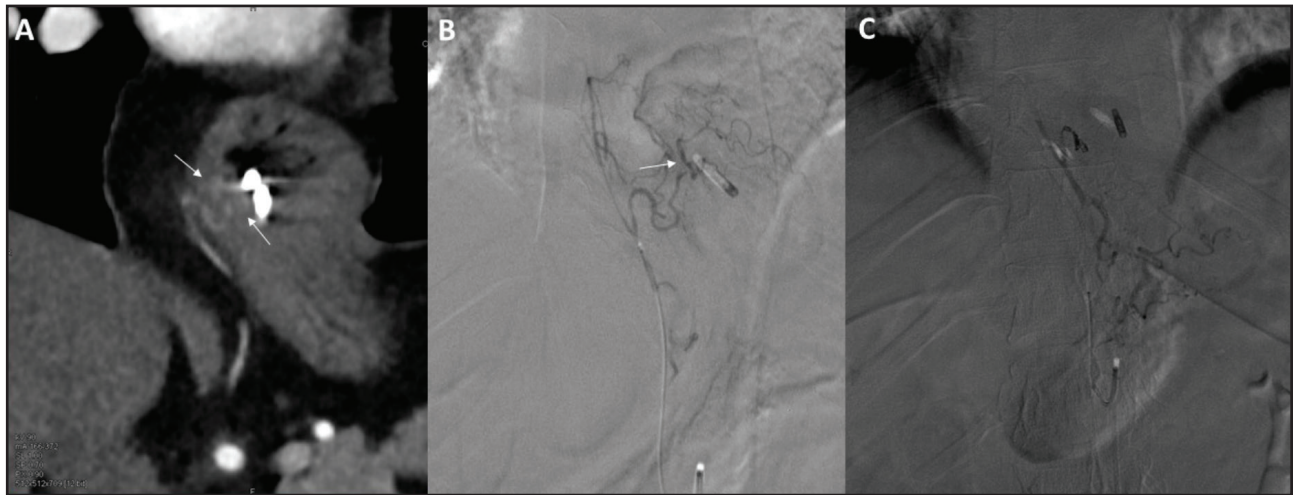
Computed tomography angiography (A) and Digital subtraction angiography (B) images obtained during the non-bleeding period show contour irregularity and slight enlargement (arrows) of the arterial branch that adjacent to the endoscopic clip (C) Digital subtraction angiography image shows occlusion of abnormal arterial branch after embolization with particles and coils.
